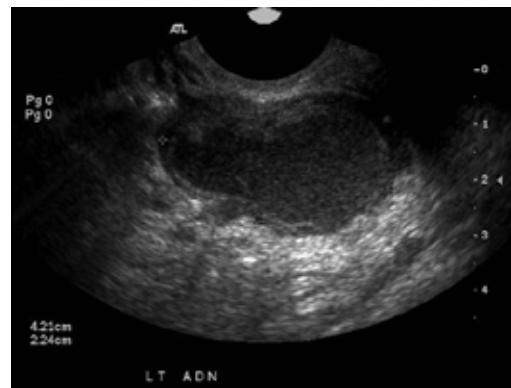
Sonographic imaging of left adnexal (LT And) TOM. Showing typical features of complex mass with multiple internal echoes.
